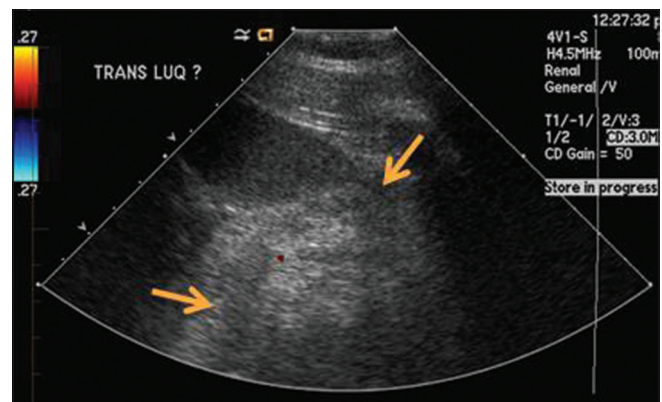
Follow-up renal ultrasound performed 1 year after starting the patient on everolimus showed mild decrease in the size of the left renal bed mass
